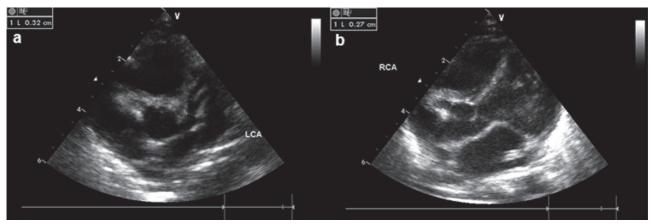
Echocardiographic pictures of this patient on day 2 after admission. (a) Left coronary artery; (b) Right coronary artery.
